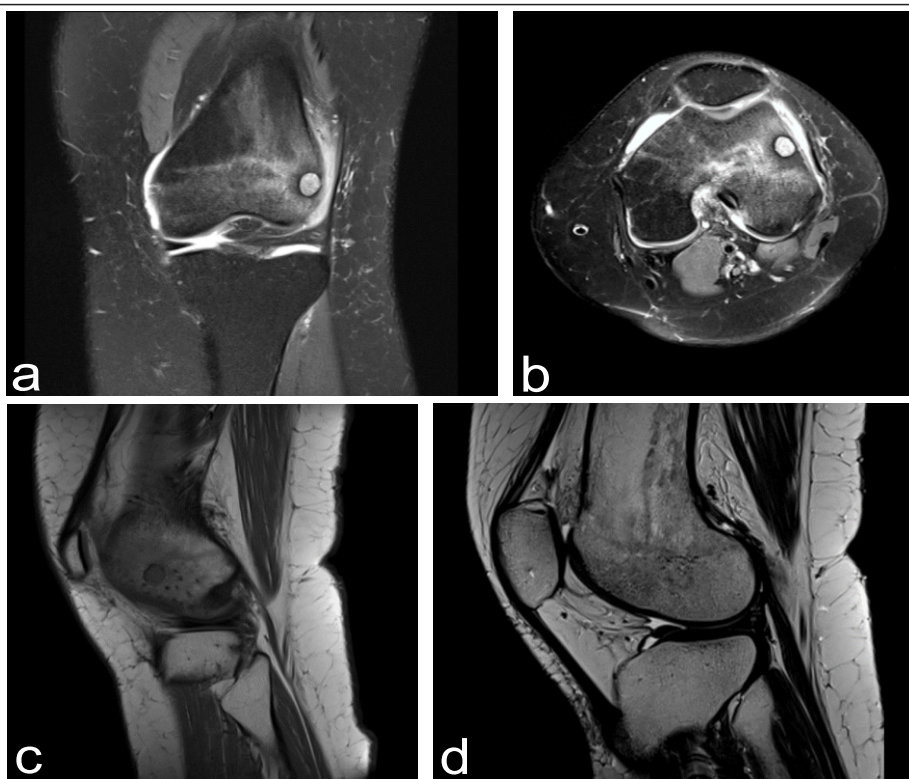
Magnetic resonance image of the left knee after the application of focused extracorporeal shockwave therapy (a) Coronal section (b) Axial section (c) Sagittal section T2 sequence (d) Sagittal section in T1 sequence.
